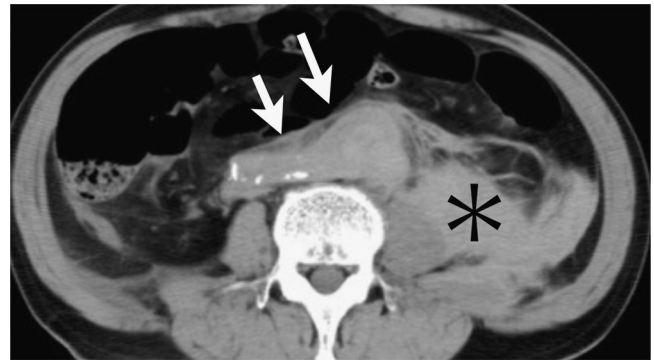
Representative PMCT image of a collapsed abdominal aortic aneurysm (AAA). CT shows an extremely deformed AAA with a shortened anteroposterior diameter (arrows). Dilatation of the aorta can only be detected by the transverse diameter. Massive retroperitoneal haemorrhage is also shown in this image (asterisk).
